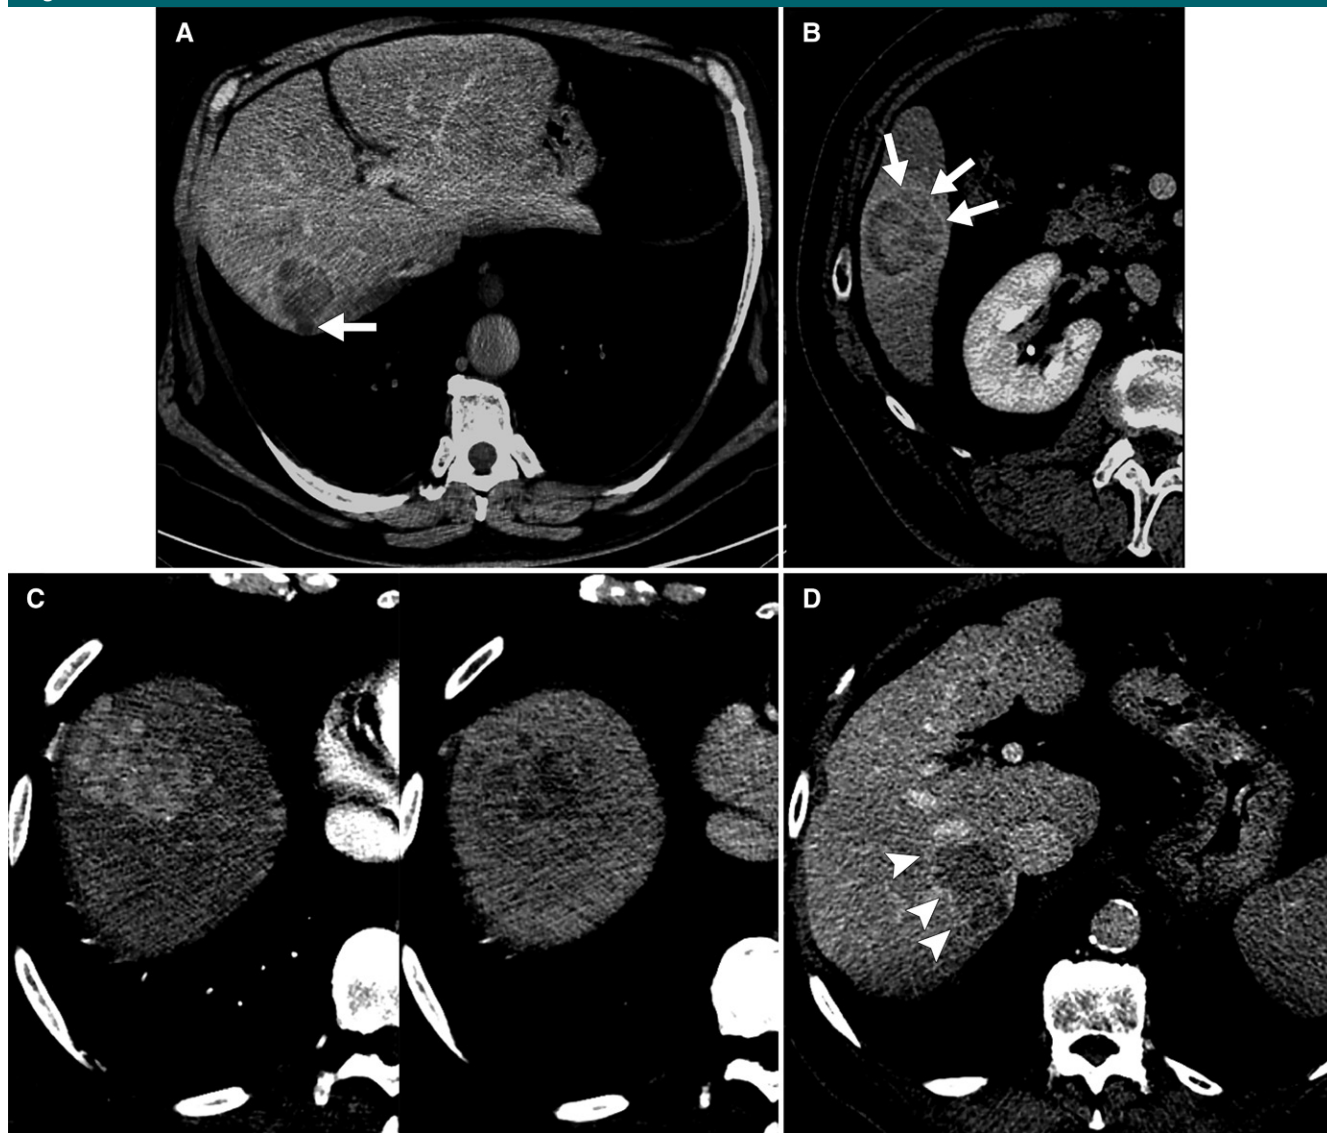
Axial CT images show a nonsmooth tumor margin, suggestive of MVI. *A*, Focal extranodular extension (arrow) in the delayed phase. *B*, Crescent extranodular extension beyond the tumor capsule (arrows) in the delayed phase. *C*, Multinodular confluent appearance in the arterial phase (left) and in the delayed phase (right). *D*, Tumor with focal infiltrative margin (arrowheads) in the delayed phase.
